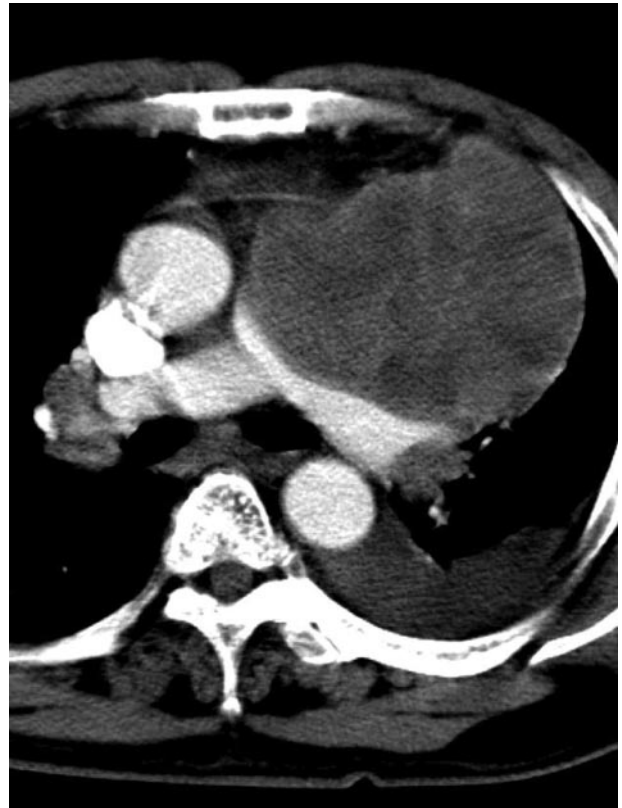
A 59-year-old man with a nonseminomatous malignant GCT. A contrast-enhanced CT scan shows a heterogeneous low-attenuating anterior mediastinal mass compressing the pulmonary artery.
